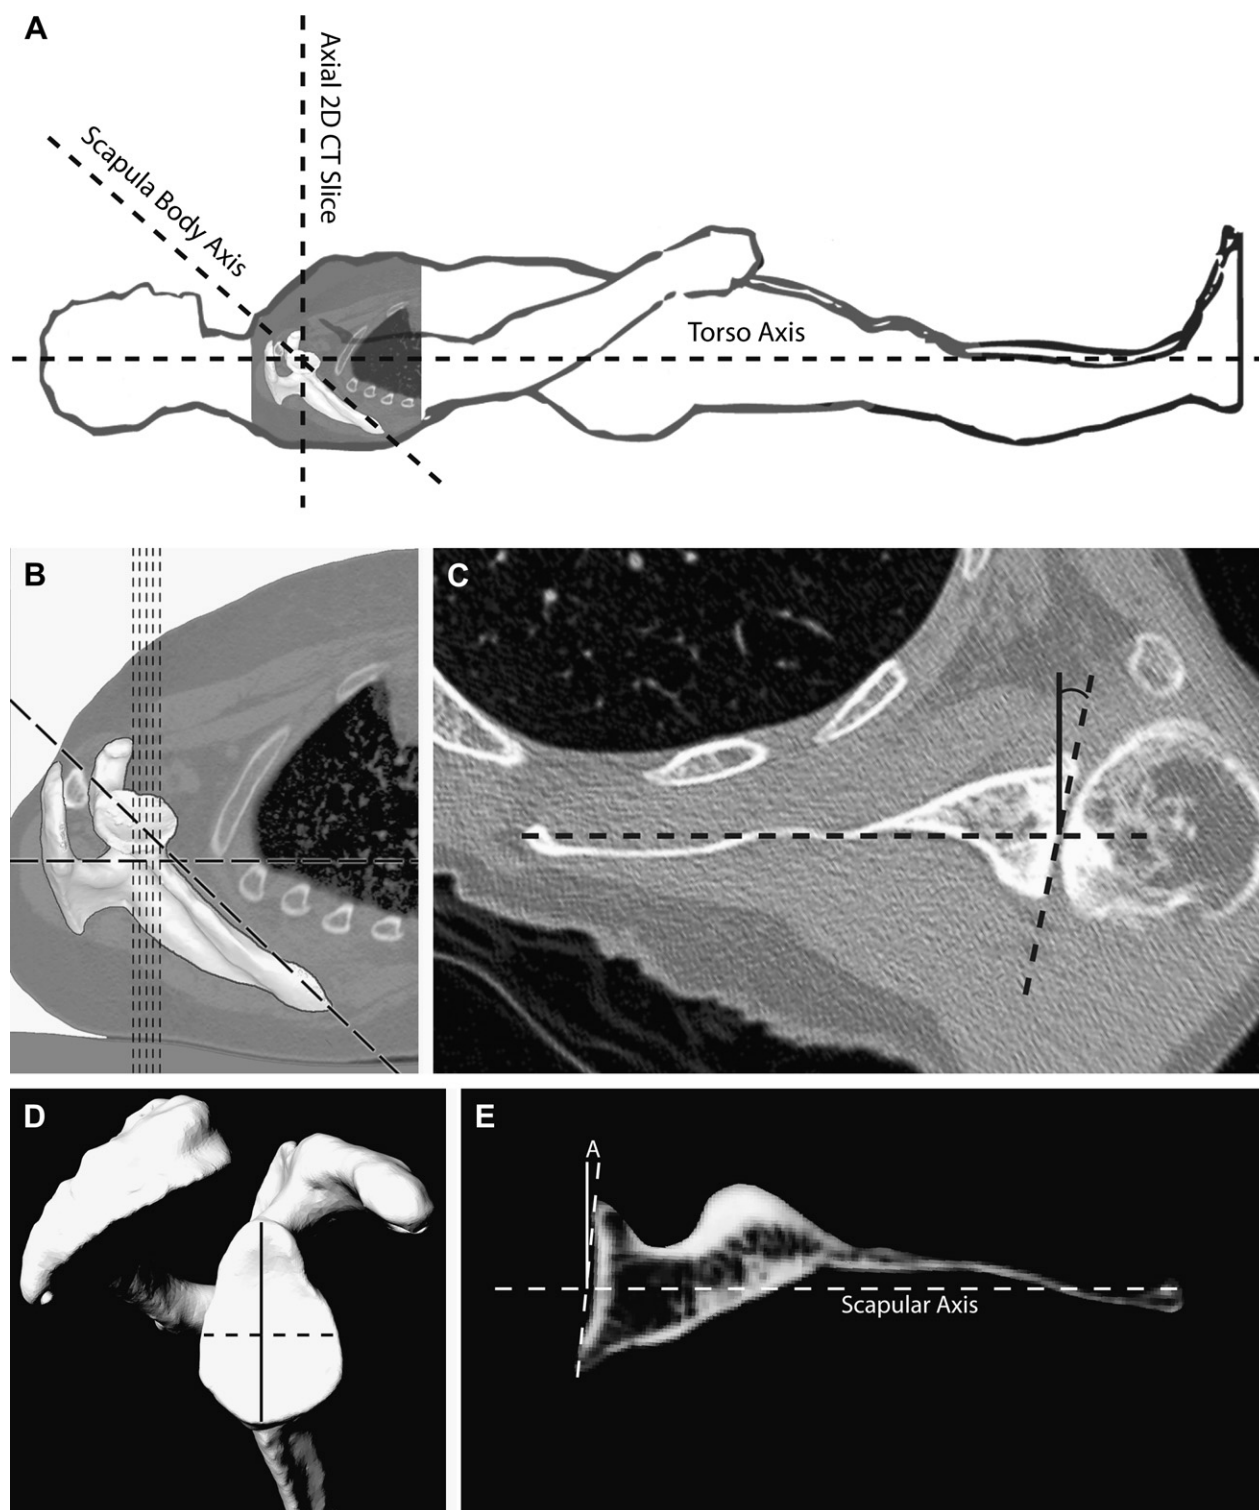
A standard axial CT scan aligned to the patient's body is not typically aligned to the scapula. (A) The vertical line shows the direction of the 2D-CT slice relative to the scapular body. (B) The 3D-CT reconstruction of a representative scapula and the orientation of 2D-CT slices at the tip of the coracoid and over a 10-mm vertical distance below the coracoid (at intervals of 2.5 mm). (C) Image of a 2D-CT slice demonstrating the method for measuring glenoid version.⁵ (D) A vertical (solid) line was drawn on the 3D surface of the glenoid face, centered in the AP direction. (E) A transverse 2D plane was generated perpendicular to the mid-point of the vertical line (dotted line in D) and passing through the scapular axis (center of the glenoid and the tip of the scapular spine). Glenoid version angle (A) was measured at the level of the transverse plane as for the 2D-CT slice.
